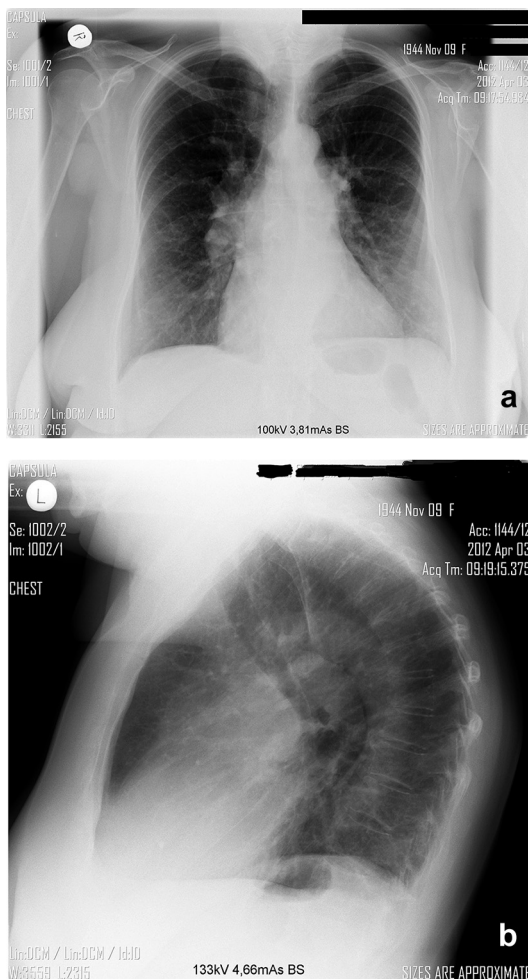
Chest x-ray (posteroanterior and lateral views). The posteroanterior (a) view shows bilaterally enlarged pulmonary hila with dominant right lung hilum. Lateral view (b) shows strongly pronounced enlarged vascular shadow.
